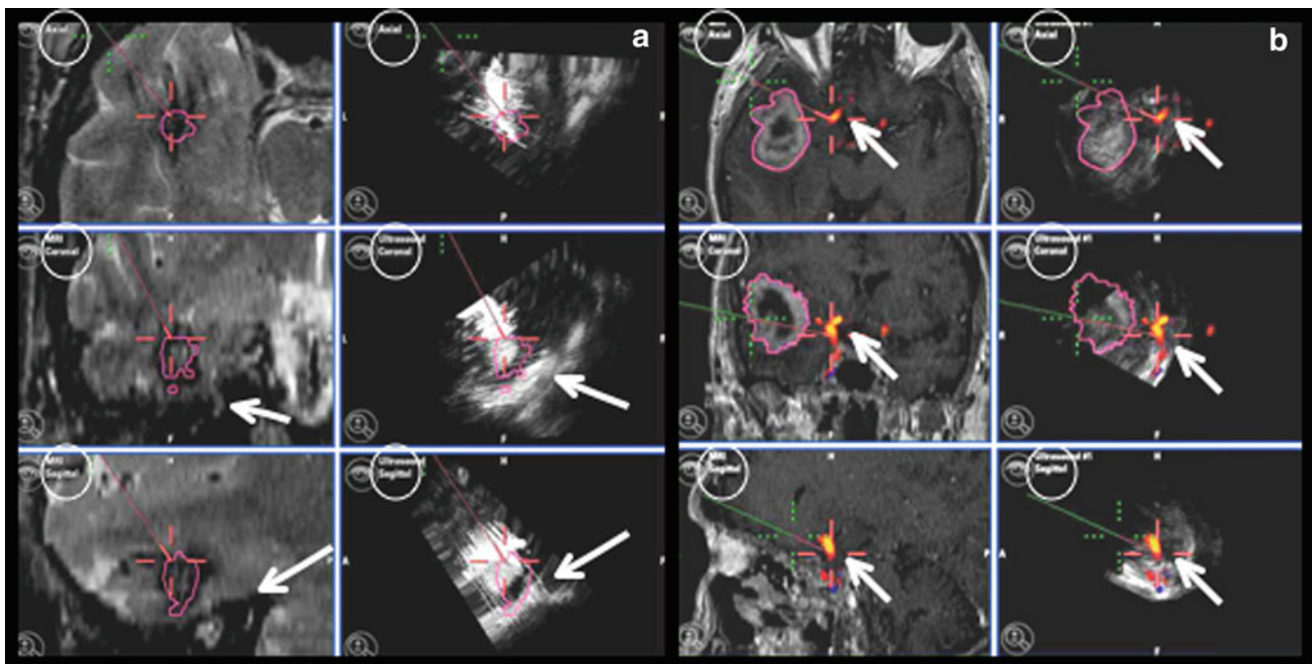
The right side of the left navigation screenshot (a) of a right temporal cavernoma displays all three familiar planes (axial, coronal and sagittal) of the 3D ultrasound reconstruction data corresponding to their preoperative navigated MRI data on the left side (highlighted by the small circles in all six windows). The arrows point to the skull base below the cavernoma (hyperintensive in ultrasound reconstruction). The right screenshot (b) includes the US angiography of the right internal carotid artery and middle cerebral artery (arrows) of a right temporal glioblastoma case (outlined preoperatively). The navigation images of the preoperative MRI and reconstructed 3D ultrasound acquisition were also placed in (b) as described above in (a)
